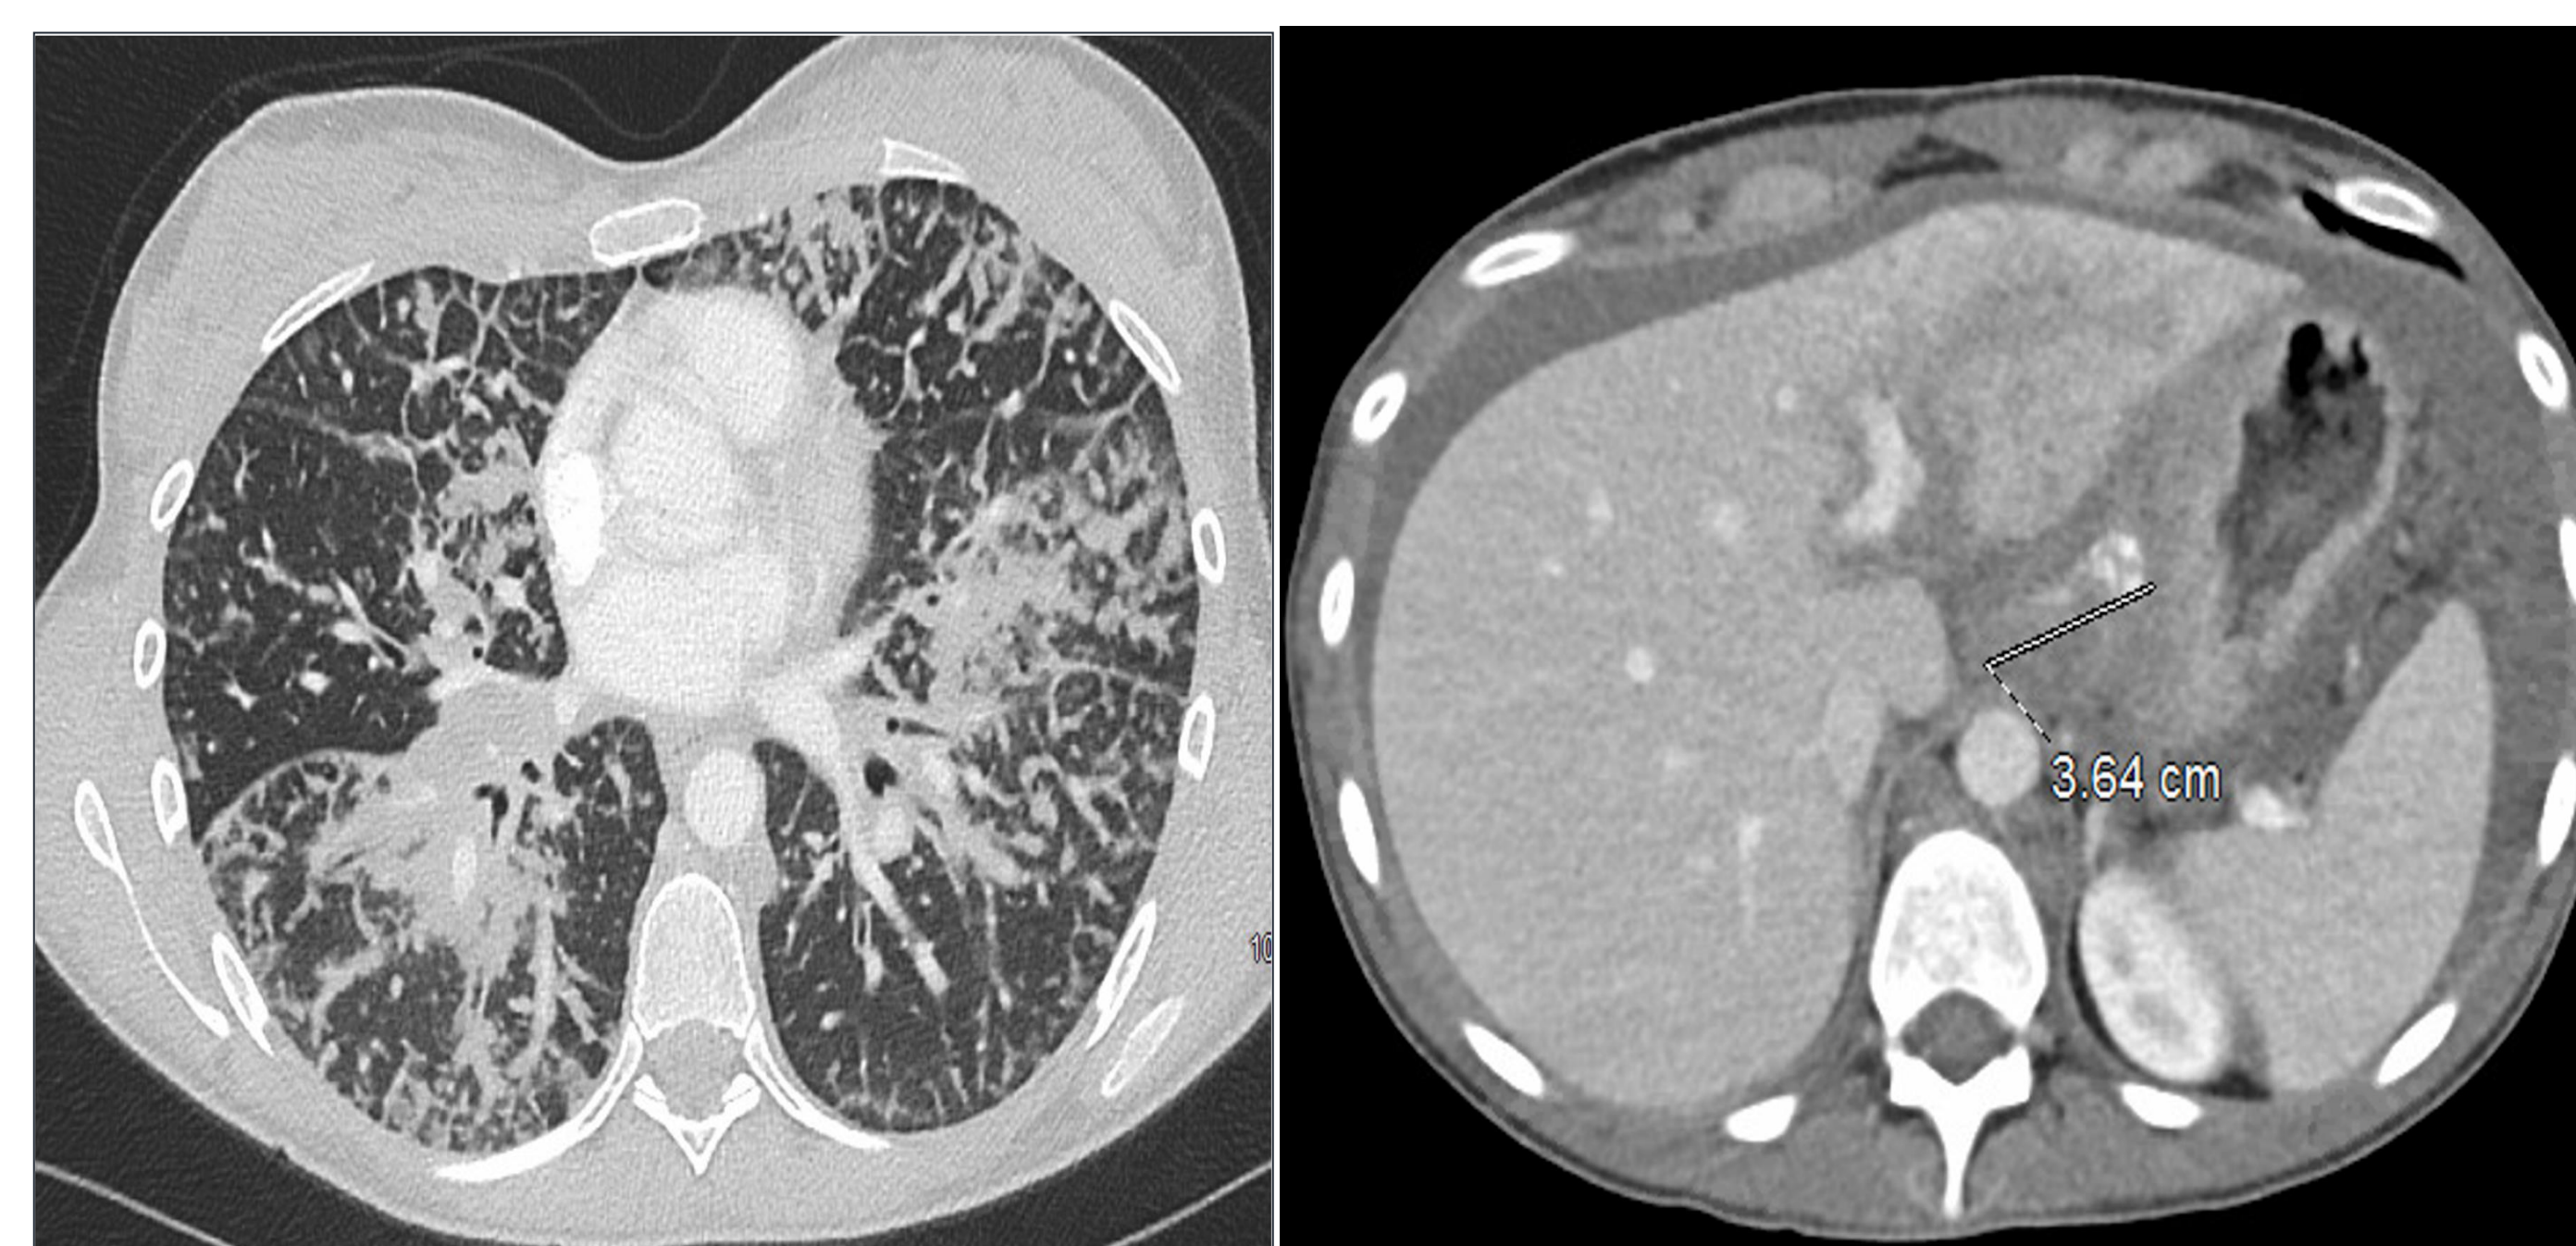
CT of chest and abdomen.
